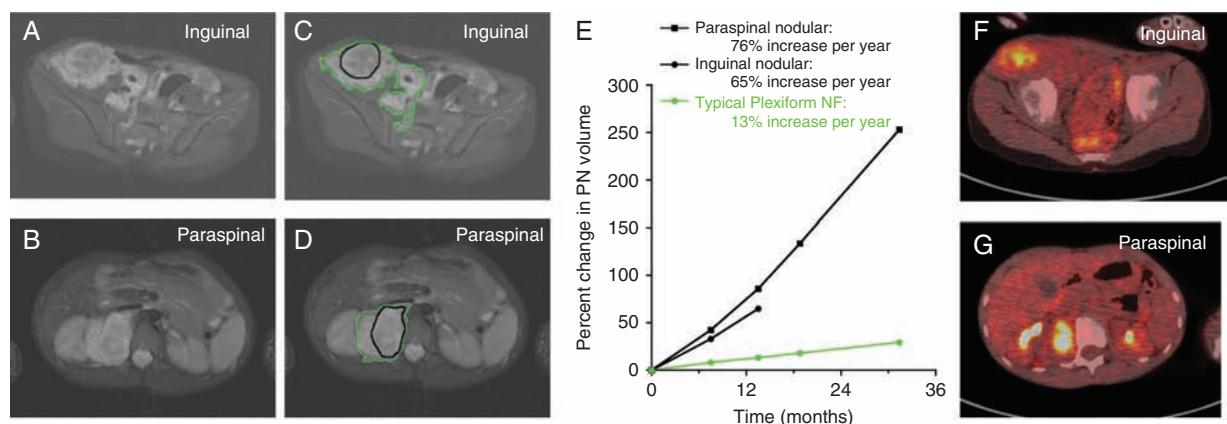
MRI and fluorodeoxyglucose (FDG) PET evaluation of 2 distinct nodular lesions within a single large PN. (A, B) A 9-year-old boy with NF1 and newly diagnosed PN involving the right retroperitoneum, pelvis, and thigh. MRI evaluation at the NCI revealed 2 distinct nodular lesions, one in the right inguinal area (A; sample ANF14-2), and one in the right paraspinal area (B; sample ANF14-1). (C–E) Volumetric MRI analysis demonstrated faster growth rates for the nodular lesions (black contour) compared with the PN (green contour). (F, G) FDG-PET demonstrated FDG avidity of the nodular lesions with minimal uptake in the surrounding PN (F and G, inguinal and paraspinal lesions, respectively). Core biopsy of the inguinal lesion showed ANF; core biopsy of the paraspinal lesion showed neurofibroma. The inguinal lesion was resected, and pathology confirmed atypical neurofibroma. Follow-up with MRI continues to demonstrate more rapid growth of the remaining paraspinal lesion compared with the PN (C, D).
